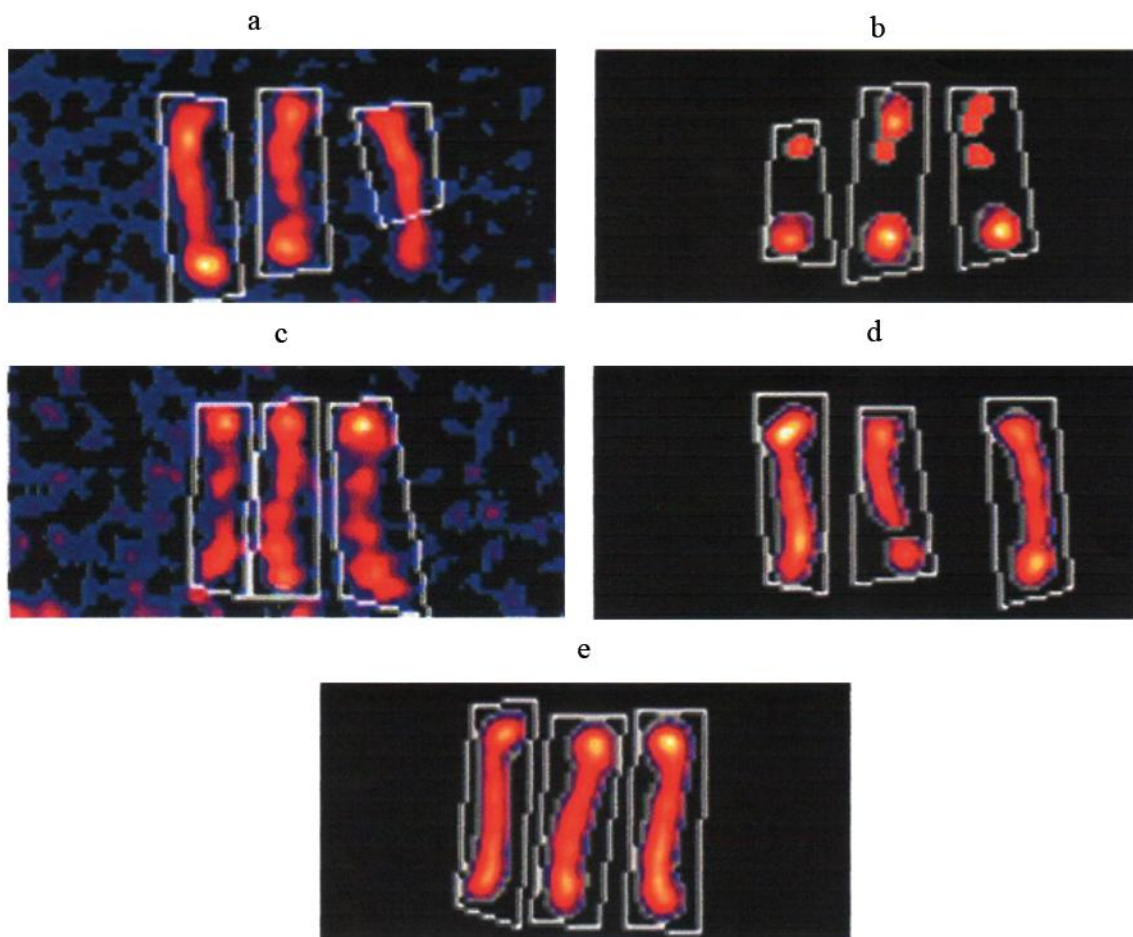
Results of BMC and BMD in femur using Dual Energy X-ray Absorptiometry (DXA) a) normal appearance of femur bone in G1, b) severely affected femur of G2, c) no adverse effects on femur of G3, d) better appearance of femur of G4 and e) The best score obtained in G5.
